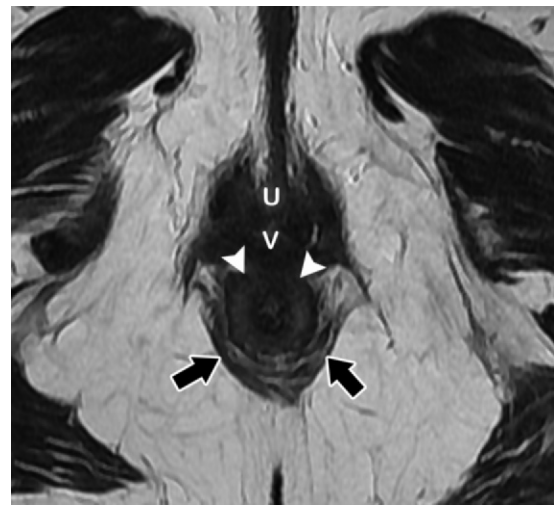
Normal appearance of anal sphincters. Axial T2-weighted image shows an internal anal sphincter (arrowheads) with uniform intermediate signal intensity, whereas the signal intensity of the external anal sphincter (arrows) is more variegated. *U* = urethra, *V* = vagina.
